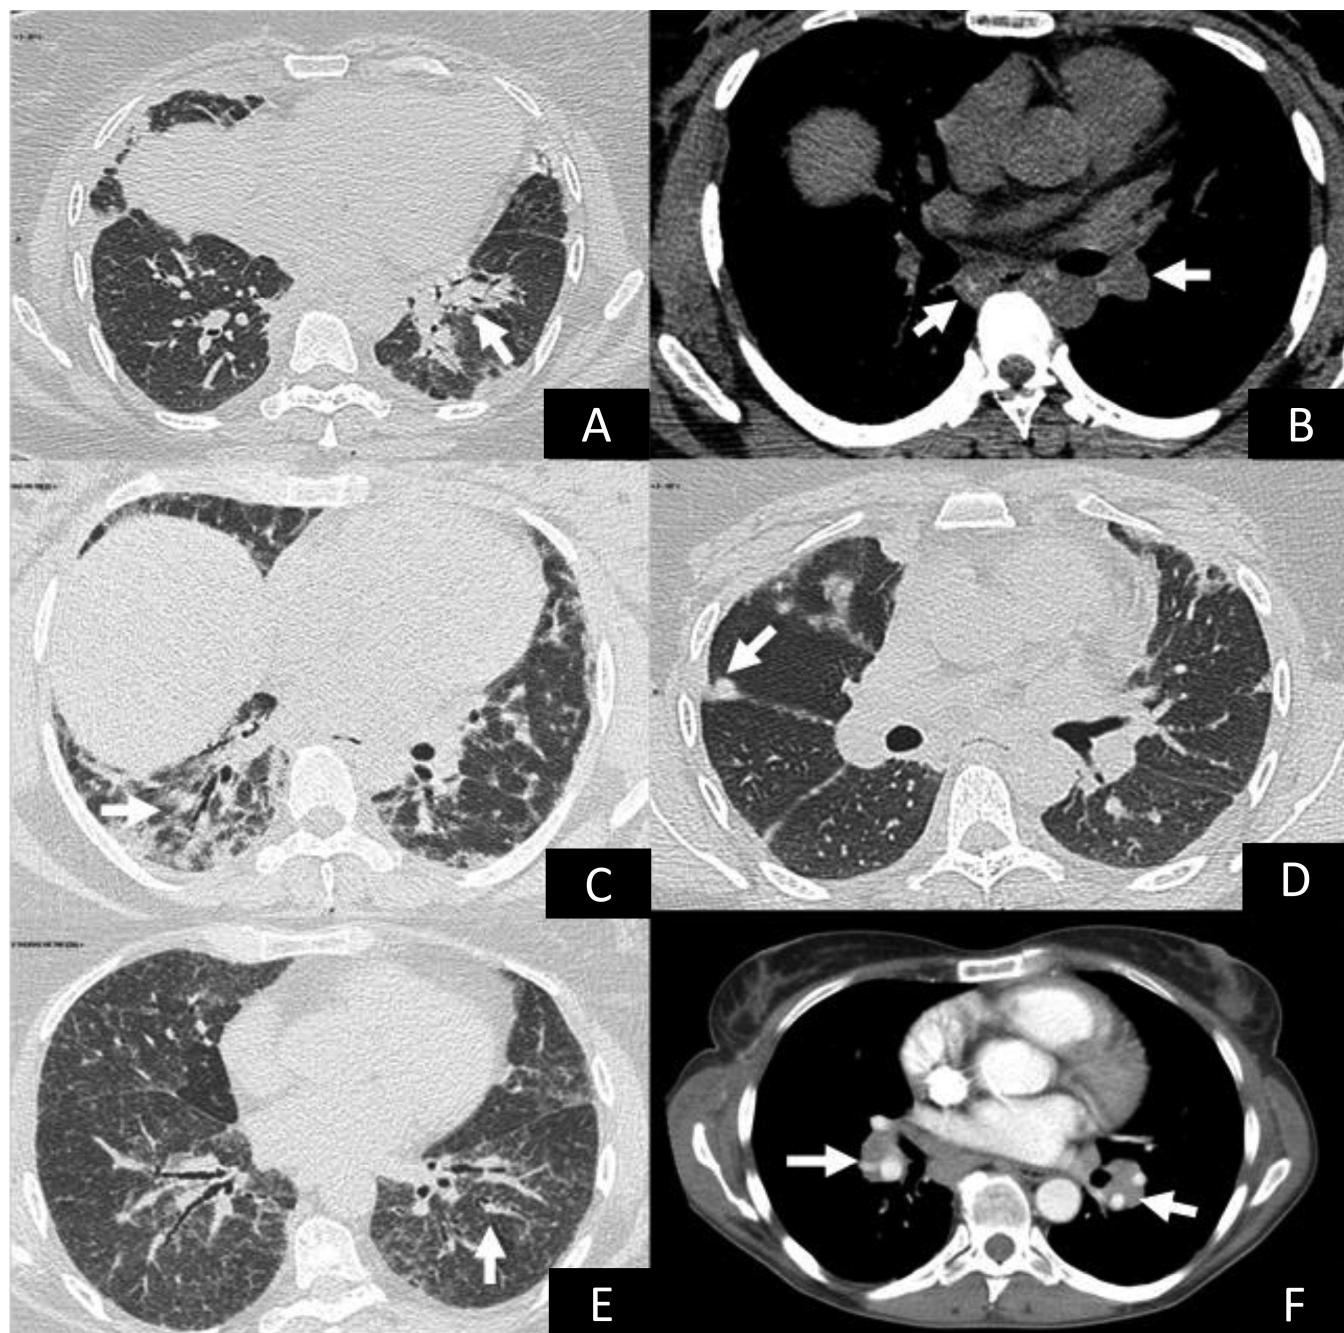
Three examples of lung CT presentations mixing features of AS and sarcoidosis. CT images on the left showed ILD pattern compatible with NSIP pattern, and CT images on the right showed lung lesions and lymph nodes well-matched with sarcoidosis features. Patient number 8 had NSIP-OP pattern with peribronchiolar condensation (A) and hilar calcified lymphadenopathies (B). Patient number 9 had NSIP pattern with proximal bronchiectasis (arrow, panel C), and subpleural reticulations with bibasal distribution; note the characteristic of intraparenchymal lymph node (arrow, panel D) with typical distribution of micronodules including fissural spreading. Patient 10 had NSIP pattern with diffuse ground glass opacities, proximal bronchiectasis, and some reticulations (E) with bilateral and symmetric enlargement of hilar lymph nodes (F). CT: computer tomography; ILD: interstitial lung disease; NSIP: nonspecific interstitial pneumonia; NSIP-OP: NSIP with organizing pneumonia.
